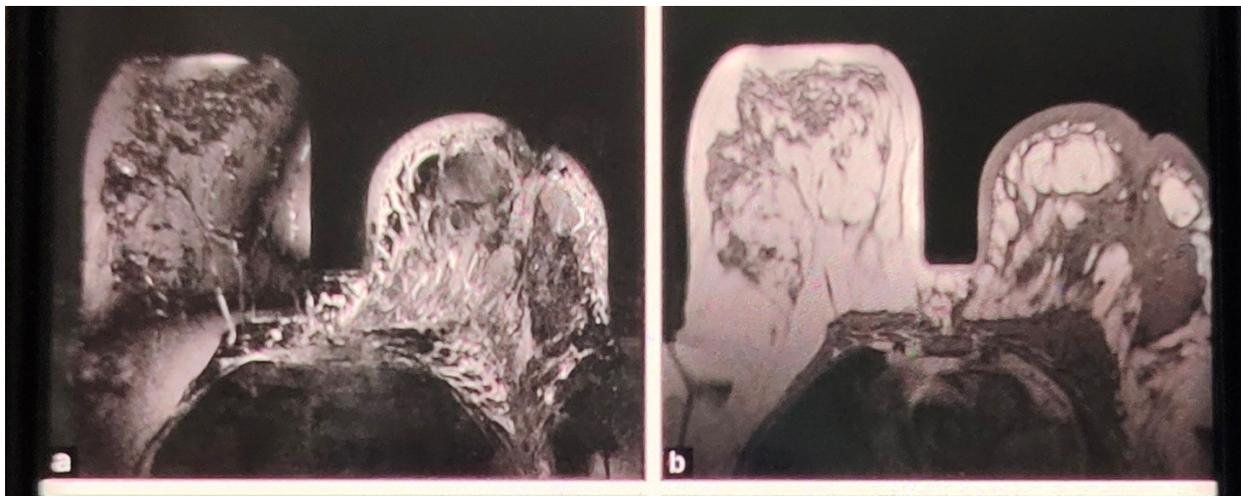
MRI breast imaging
